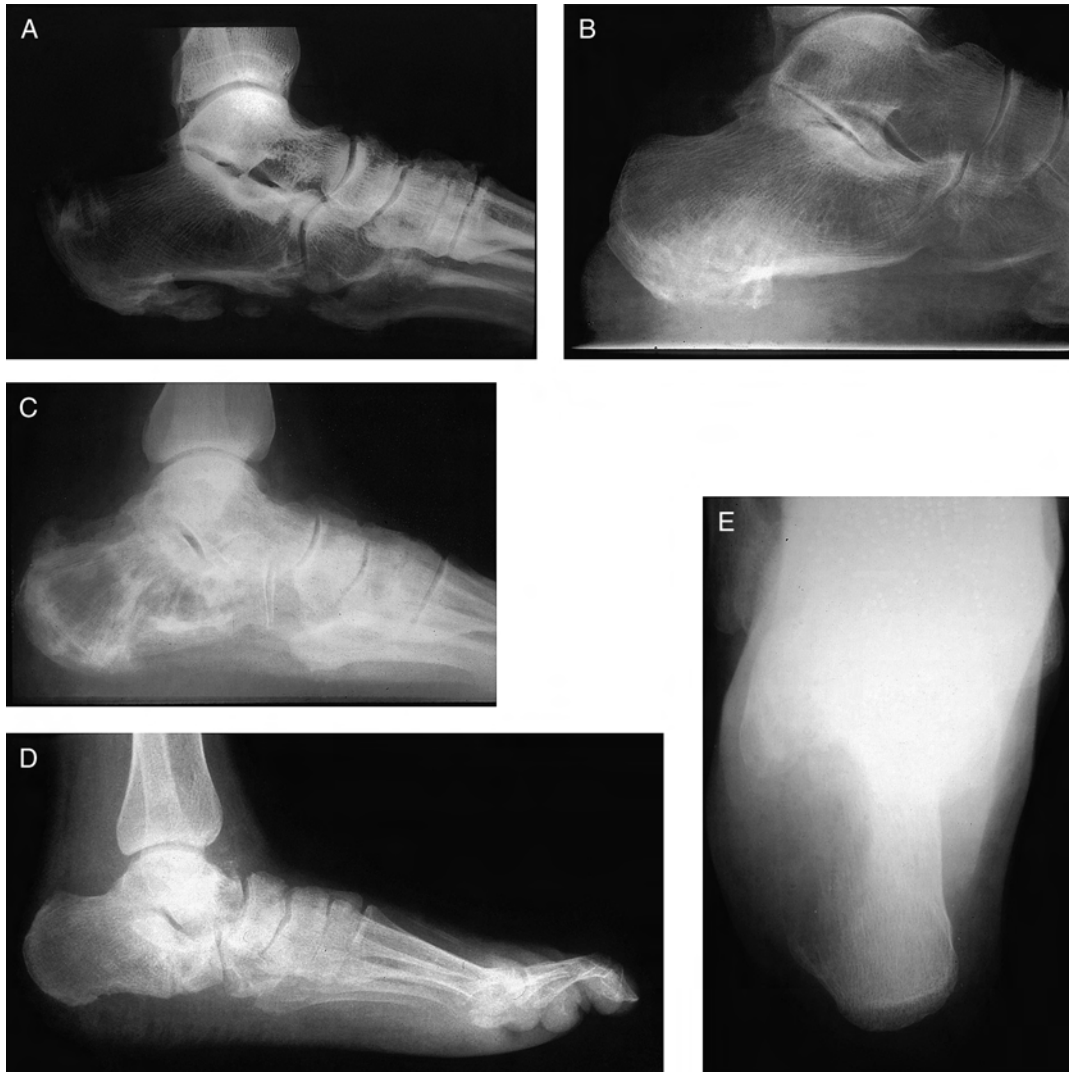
As depicted in these radiographs, very diverse pathologies may be responsible for heel pain. These include (A) proliferative enthesopathies, DISH (diffuse idiopathic skeletal hyperostosis) with ossification within the plantar fascia; (B) Reiter's disease with fluffy periostitis of the inferior tuberosity; (C) Paget's disease with a "moth-eaten" ground glass bone density; (D) neuropathic fracture in a patient with diabetes; and (E) malignant bone tumor in a young male with a large lytic lesion of the lateral calcaneal wall.
